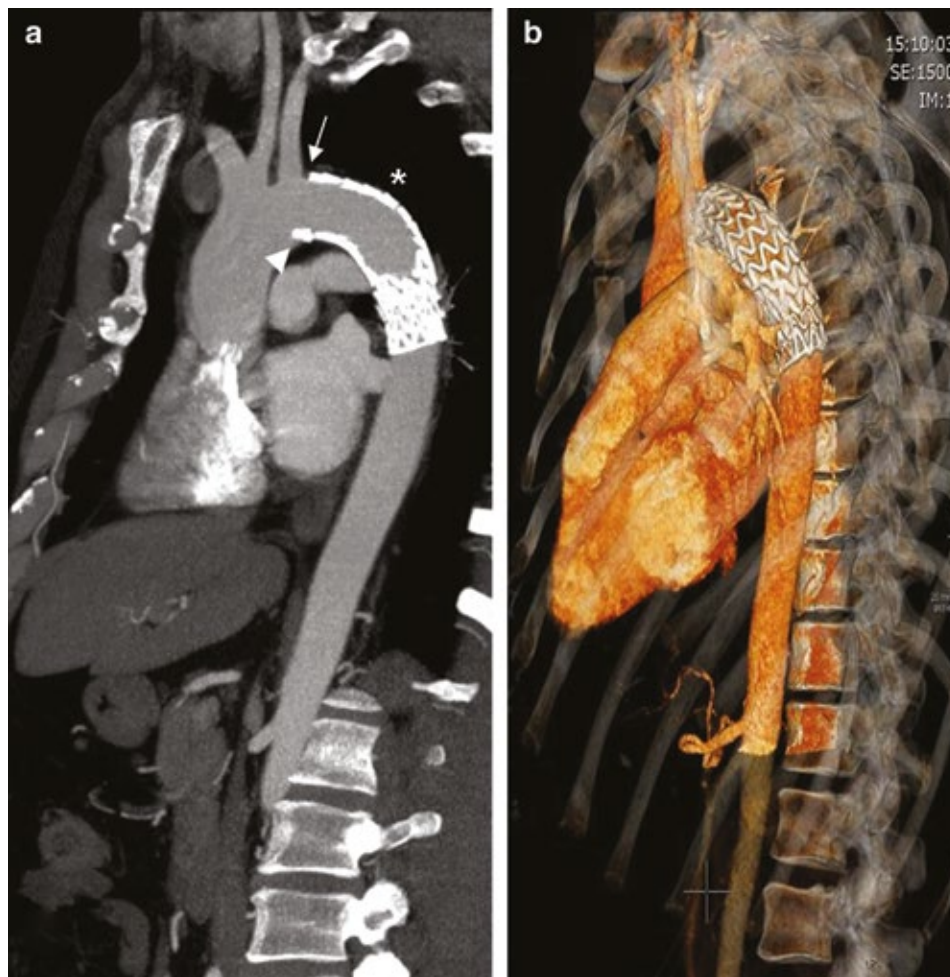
(a) Parasagittal MIP shows the exclusion of posterior descending aortic pseudoaneurysm (PDAP) with the correct positioning of the endograft (asterisk). The image demonstrates the graft at the ostium of the left subclavian artery (white arrow) with minimum "bird beak sign" (white arrowhead). (b) CT 3DVR highlights the endograft treating the PDAP.
